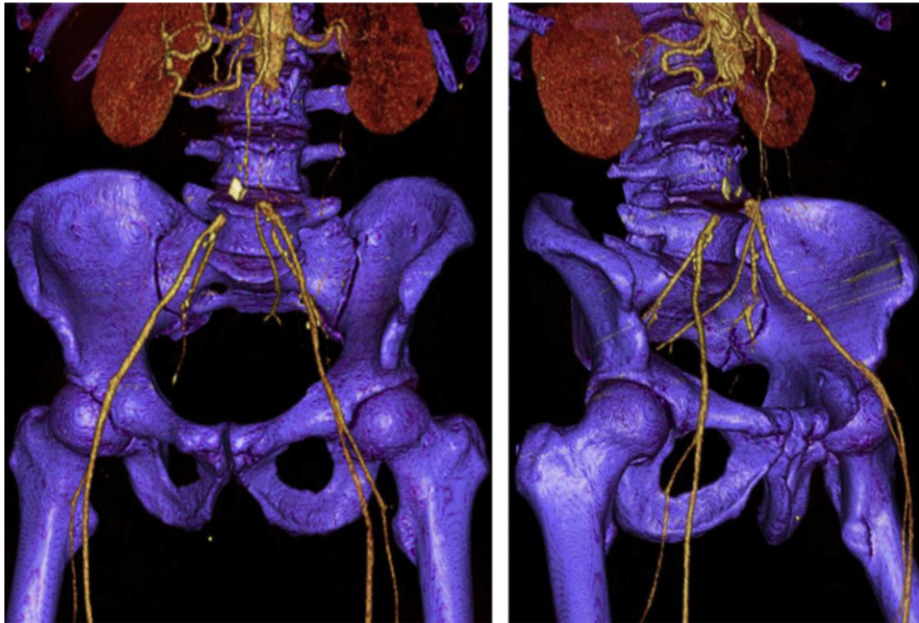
Thoracoabdominal CTA.
